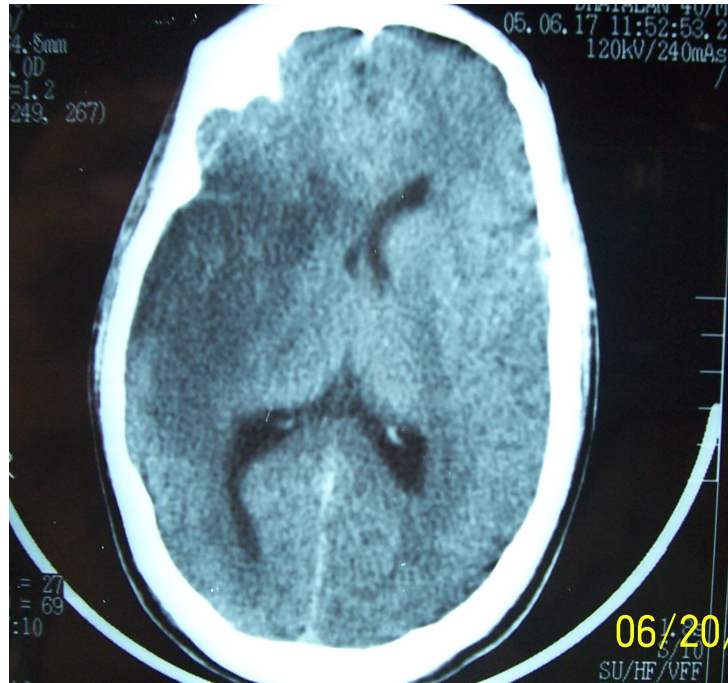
b CT SCAN OF A PATIENT WITH BROCA'S APHASIA
